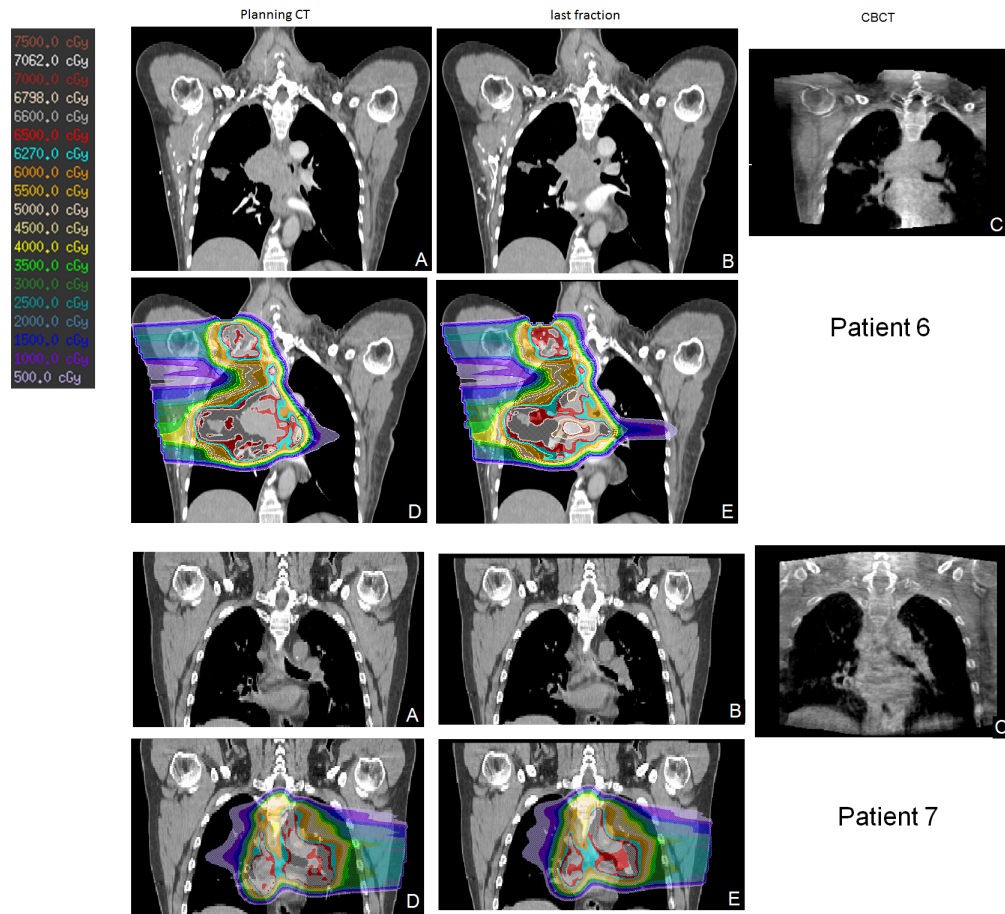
Planning CT (A) and the modified CT (B) of the last fraction of Patient 6 (top) and Patient 7 (bottom) with the planned dose (D) and the recalculated dose (E) on the modified CT. Daily CBCT (C) is used to deform the planning CT to the modified CT.
